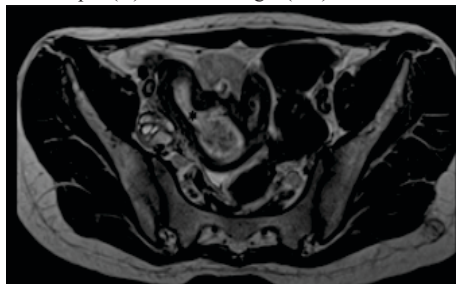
Non contrast axial T2 weighted MRI image showing communication of the pelvic mass with the right horn (*)
